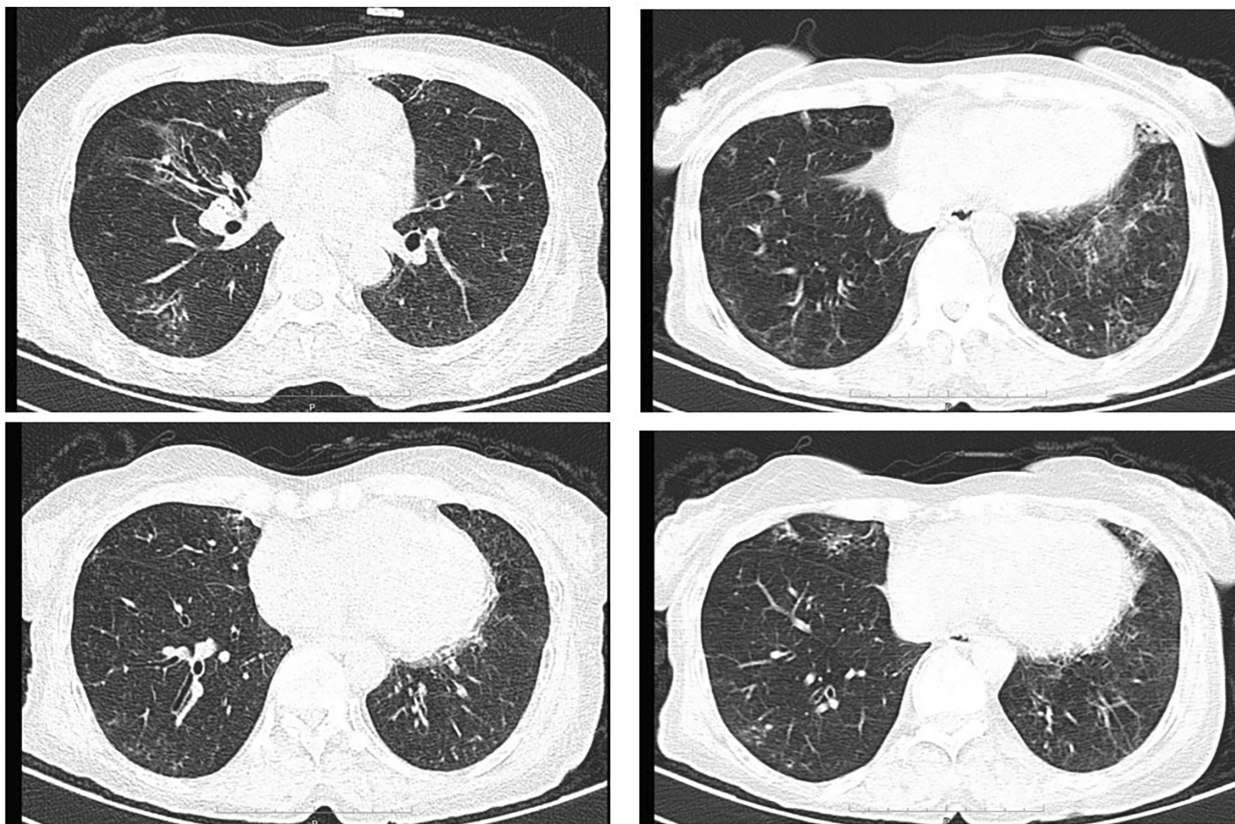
The spiral lung computed tomography scan showed the presence of centrilobular nodules exhibiting tree-in-bud patterns alongside bronchiectasis, predominantly located in the middle and lower regions of the lungs. No pleural effusion was detected.
